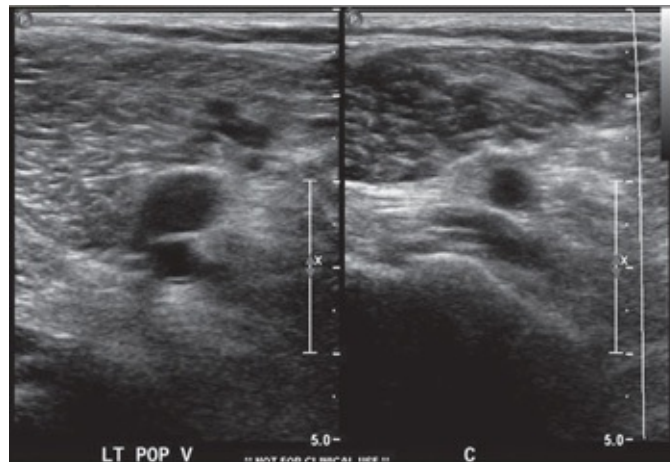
Abnormal DVT ultrasound; noncompressible popliteal vein.
